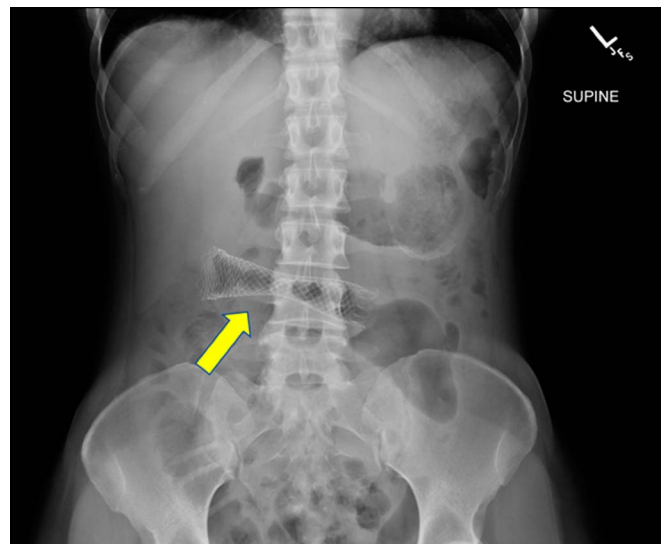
Abdominal x-ray demonstrating a 22 × 90-mm uncovered self-expanding metal stent (yellow arrow) placed through the stricture at the transverse colon.
